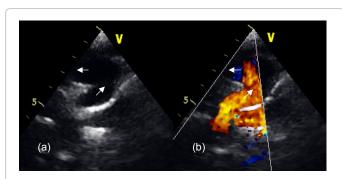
Suprasternal two dimensional echocardiographic image of the abnormal connection to the left innominate vein (a). Color Doppler image of the abnormal drainage to the left innominate vein (b). Arrows show the direction of blood flow. These echocardiographic images are the respective of the angiographic images of Figure 3.
